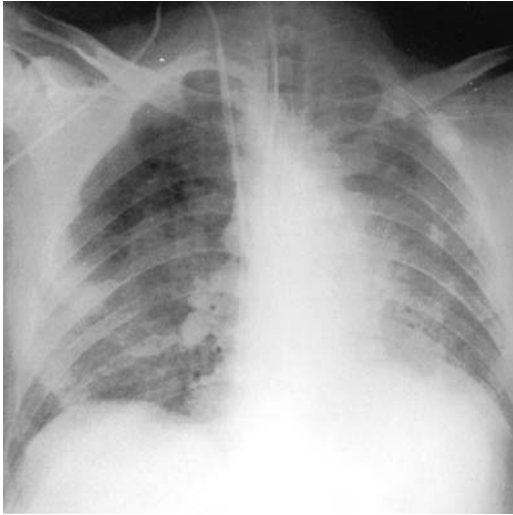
Anteroposterior chest x-ray showing diffuse ground glass opacification, sparing the right upper lung. Published with permission from [18]
